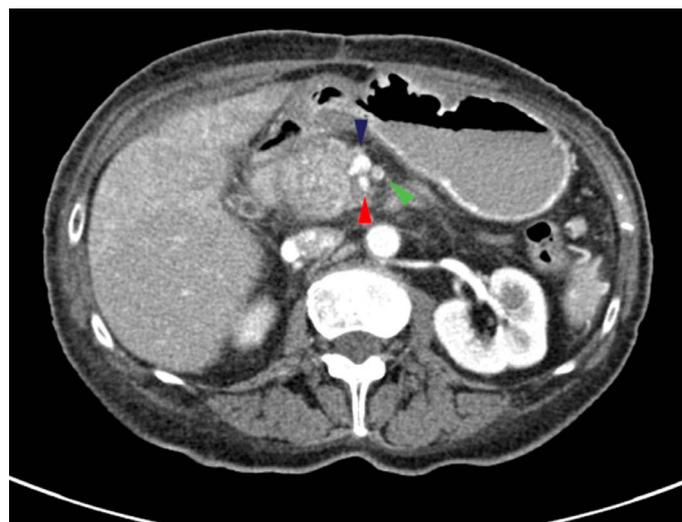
Computed tomography with a contrast showing the tumor within the head of the pancreas. (blue arrow - portal vein, green arrow - superior mesenteric vein, red arrow: superior mesenteric artery).
